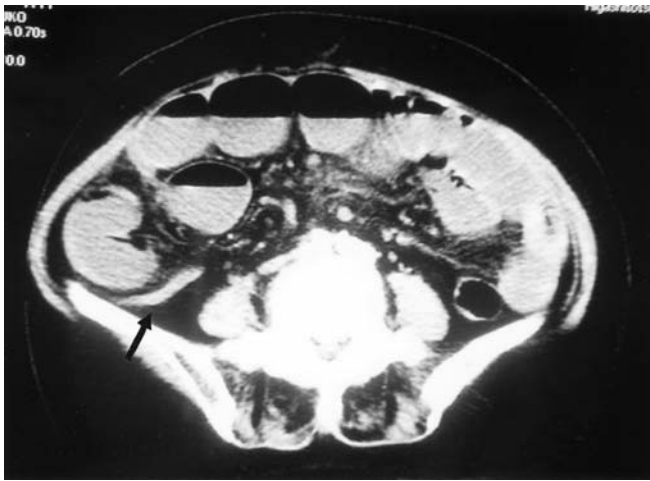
Computed tomography (CT) scan (first medical examination) of the emptied ascending colon (*arrow*)
